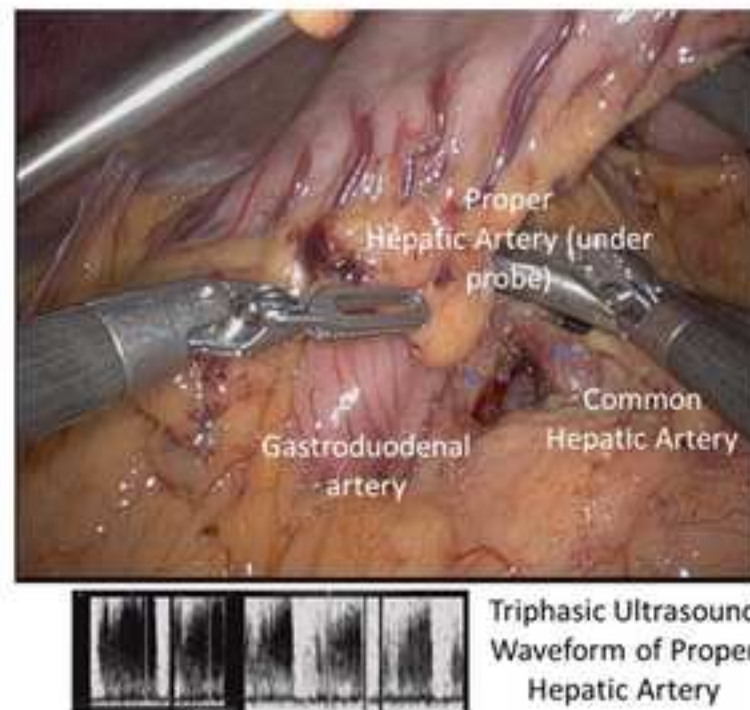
Dissection of porta hepatis with identification of common and proper hepatic artery and gastroduodenal artery with triphasic ultrasound signal
